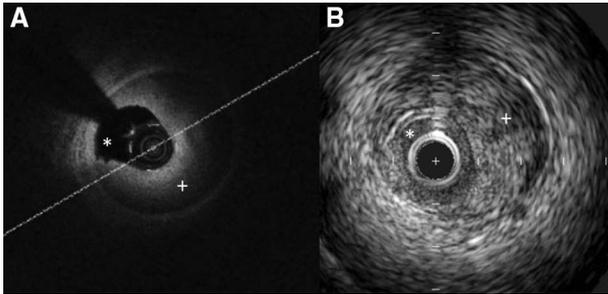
A, Optical coherence tomography showing blood in the artery wall (+) compressing the true lumen (*). B, Intravascular ultrasound showing blood in the artery wall (+) compressing the true lumen (*).
